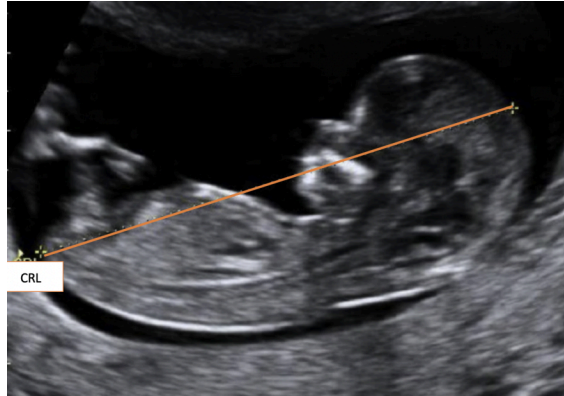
CRL measurement by ultrasound (77)
